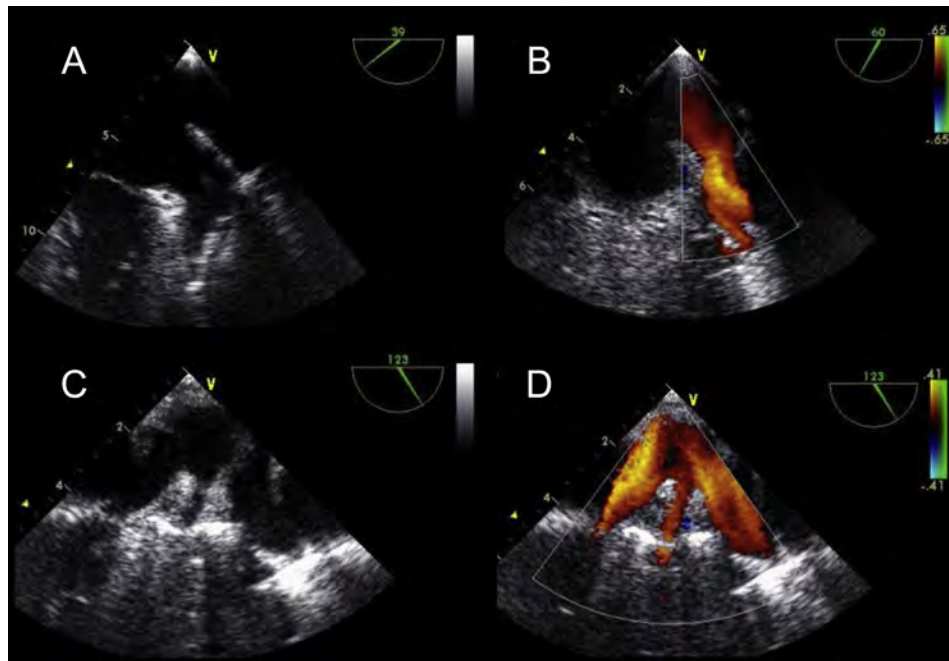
TEE demonstrating left pulmonary veins in two different views. Midesophageal views (A) without and (B) with color flow Doppler obtained at 60° (mitral commissural view) with the probe then rotated slightly to the left to reveal the left-sided pulmonary veins. Midesophageal long-axis views with the probe rotated toward the left pulmonary veins at 120° (C) without and (D) with color Doppler.
